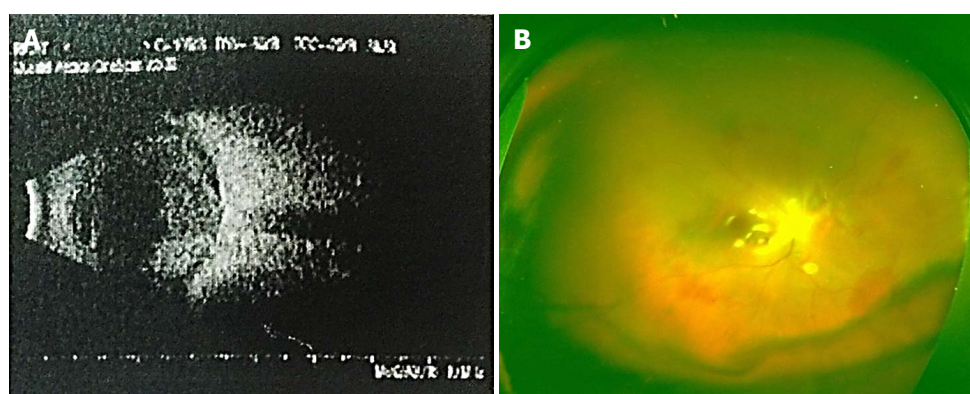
Clinical findings in patient 4. A: An ultrasound showed massive suprachoroidal hemorrhage with choroidal detachment; B: The choroidal detachment was completely reduced after surgery.
